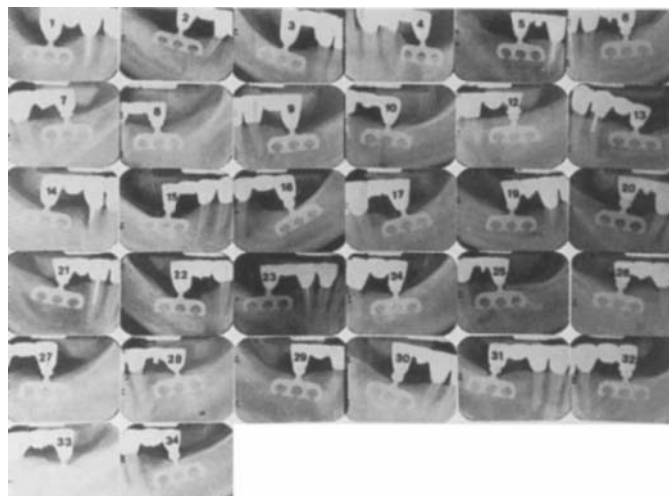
■ Representative radiographs of patients in the NIH/Harvard plate/blade form study.
